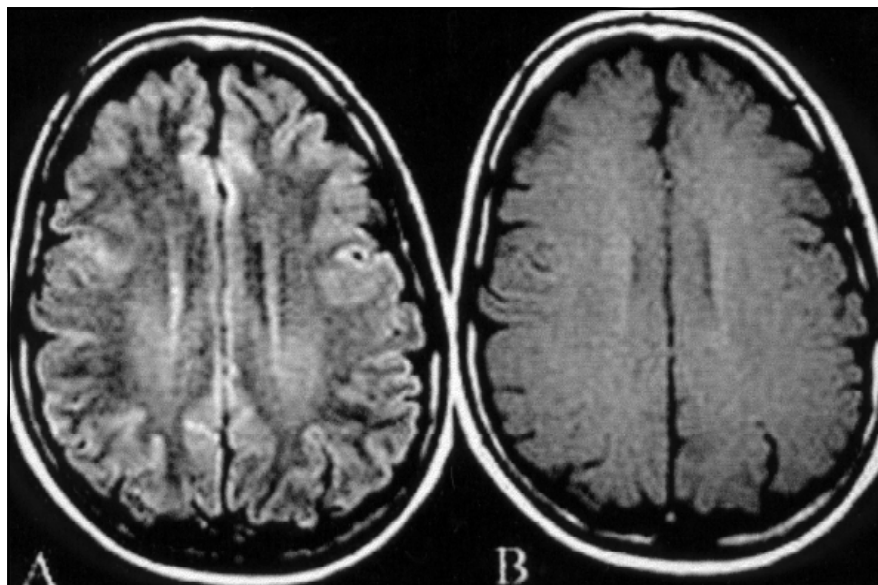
Healthy subject. A- Axial FLAIR showing hyperintensity of the pyramidal tracts extending from the internal capsule to the subcortical region of the precentral giri. B- axial T1/SE/MT: no abnormal findings are seen.
